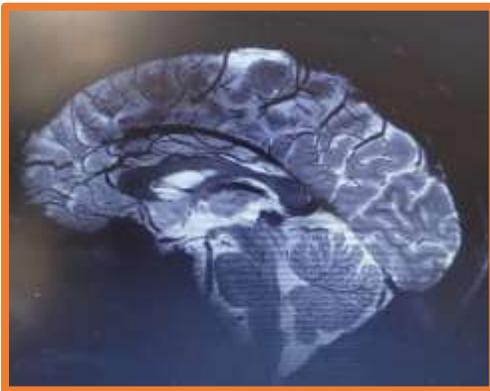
Image of a human brain captured with the Iseult MRI machine at 11.7 Teslas.
